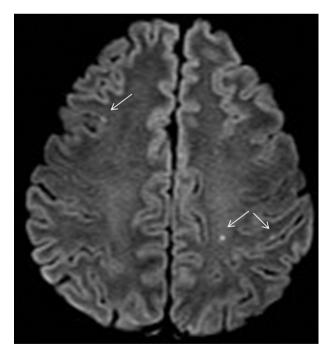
Fifty-five-year-old woman presenting with transient (10 min) right hand paresia, lasting 10 minutes. MRI performed 10 hours after the onset of symptoms. Small hyperintensities in left and right hemispheres (arrows) on DWI. Etiological work-up: atrial fibrillation.
